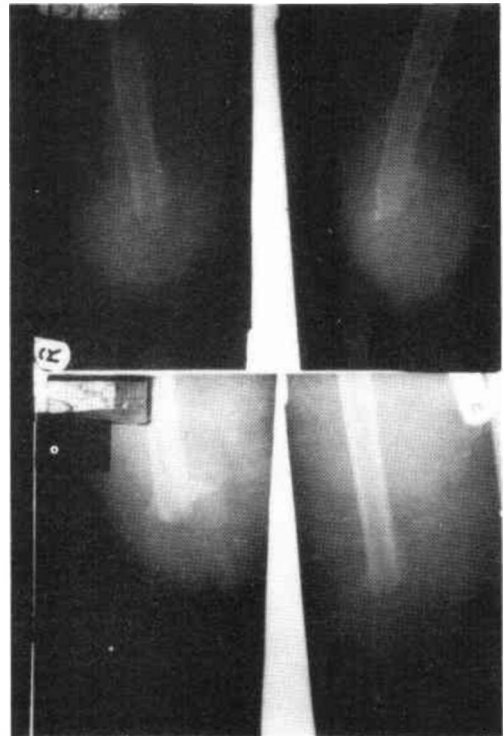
Chronic osteomyelitis of an above-knee femoral stump. Two small sequestra, visible in the top films, have been removed, as can be seen in the post-operative x-rays.
